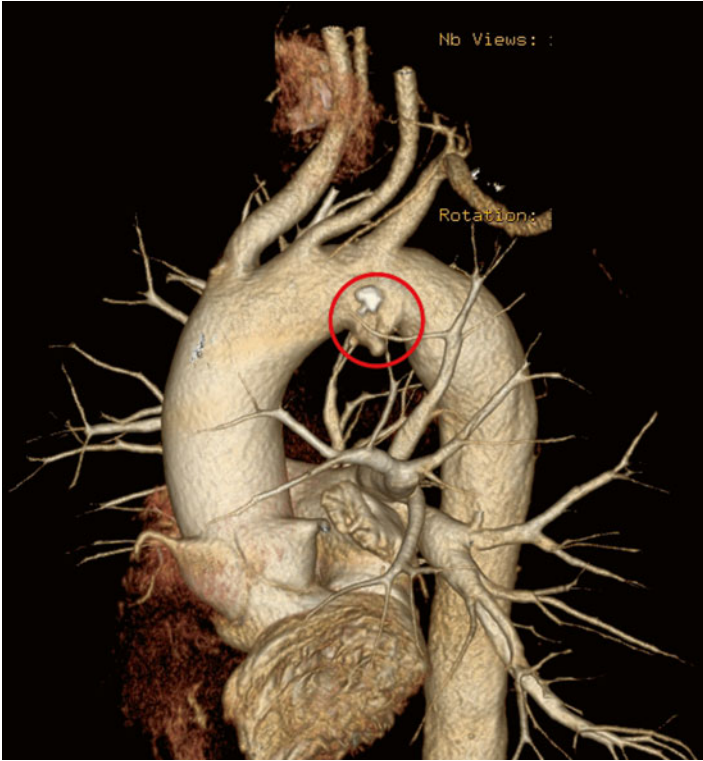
Multi-slice CT scan reconstruction in a patient with mycotic aneurysm of the aortic arch (*encircled in red*). The typical appearance of a small saccular aneurysm due to infectious aortitis (from *Escherichia spp.* in this patient) is evidenced, with its irregular profile due to multiple out-pouches. Location of the lesion is also typical, i.e. opposite the origin of aortic branches
